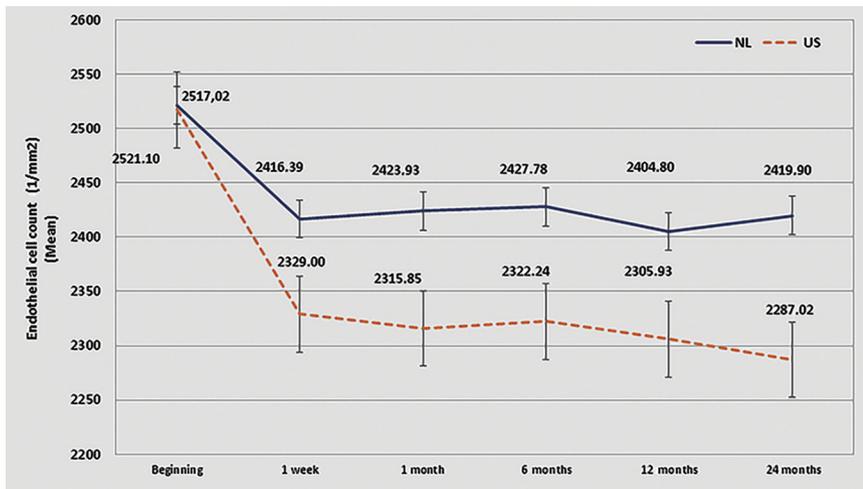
The ECD dynamics over a 24-month period (*P* < .001) (NL = nanosecond laser; US = ultrasound).
